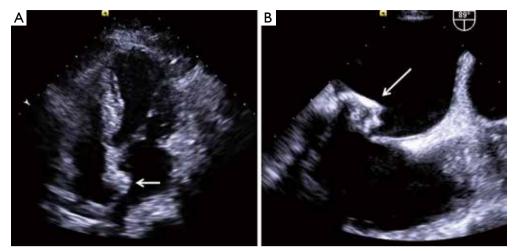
(A) Transthoracic (B) and transesophageal echocardiography revealed a calcified mass in the left atrium. White arrow indicates the mass.
